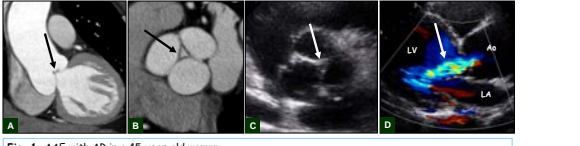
AAE with AR in a 45-year-old woman. Multiplanar reformatted CT images (A, B) - Aortic root dilatation with triangular coaptation defect (arrows) on mid-diastole. Echocardiographic images (C, D) - Incomplete coaptation of aortic valve (C, arrow) and central moderate AR (a jet regurgitating into the left ventricle) (D, arrow)
